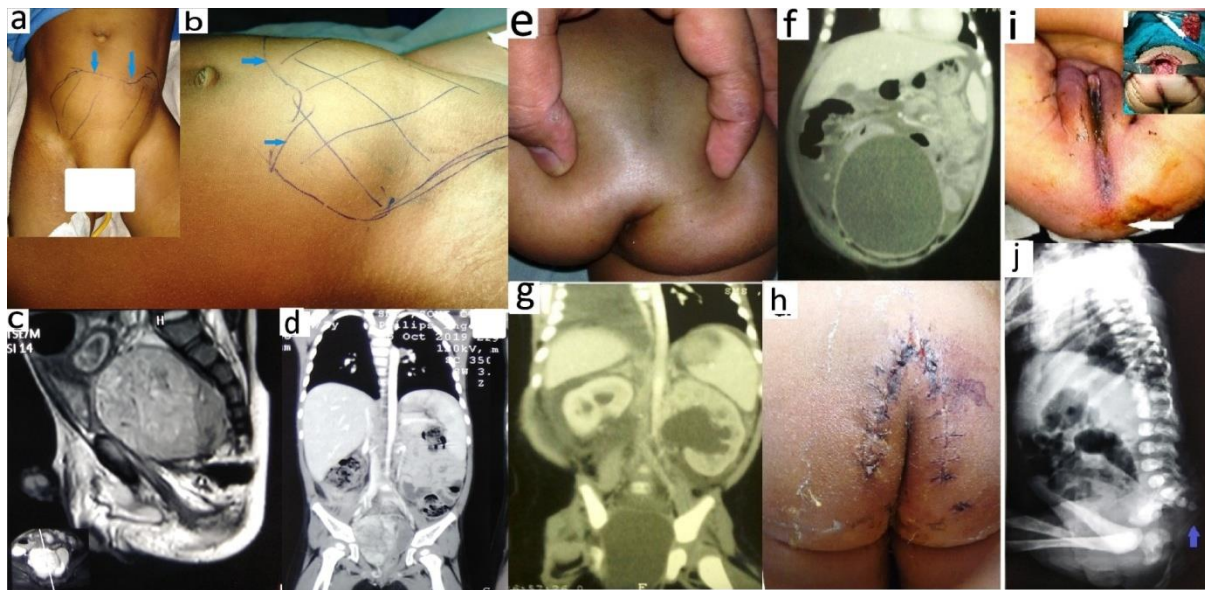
Clinical photographs show (a and b) a 2 year old female child with a large pelvic mass extending in the suprapubic region (blue arrow) having Altman type IV and Benachi type B SCT. Radiological Images of a 2-year old male child with Altman type IV sacrococcygeal teratoma: (c) Magnetic Resonance Imaging (MRI) sagittal image show a large pelvic tumour arising from the sacrococcygeal region. (d) Contrast Enhanced Computed Tomography (CECT) coronal section images reveal a heterogenous density tumour limited to the pelvic cavity. Clinical photograph shows (e) a female infant with sacral swelling. Contrast Enhanced Computed Tomography (CECT) abdomen and pelvic images (f and g) show a large pelvic cyst arising from the sacrococcygeal region with Altman type III and Benachi type A causing bilateral hydroureteronephrosis. (h) Postoperative scar of chevron incision. Clinical photographs show (i with inset image) a 2 day old female neonate with sacrococcygeal teratoma (white arrow) and absent anal opening; tumour bed following excision of tumour along with coccyx. Lateral radiographs show absent lower sacral vertebra (indigo arrow) with posteriorly positioned sacrum due to presence of tumour.
